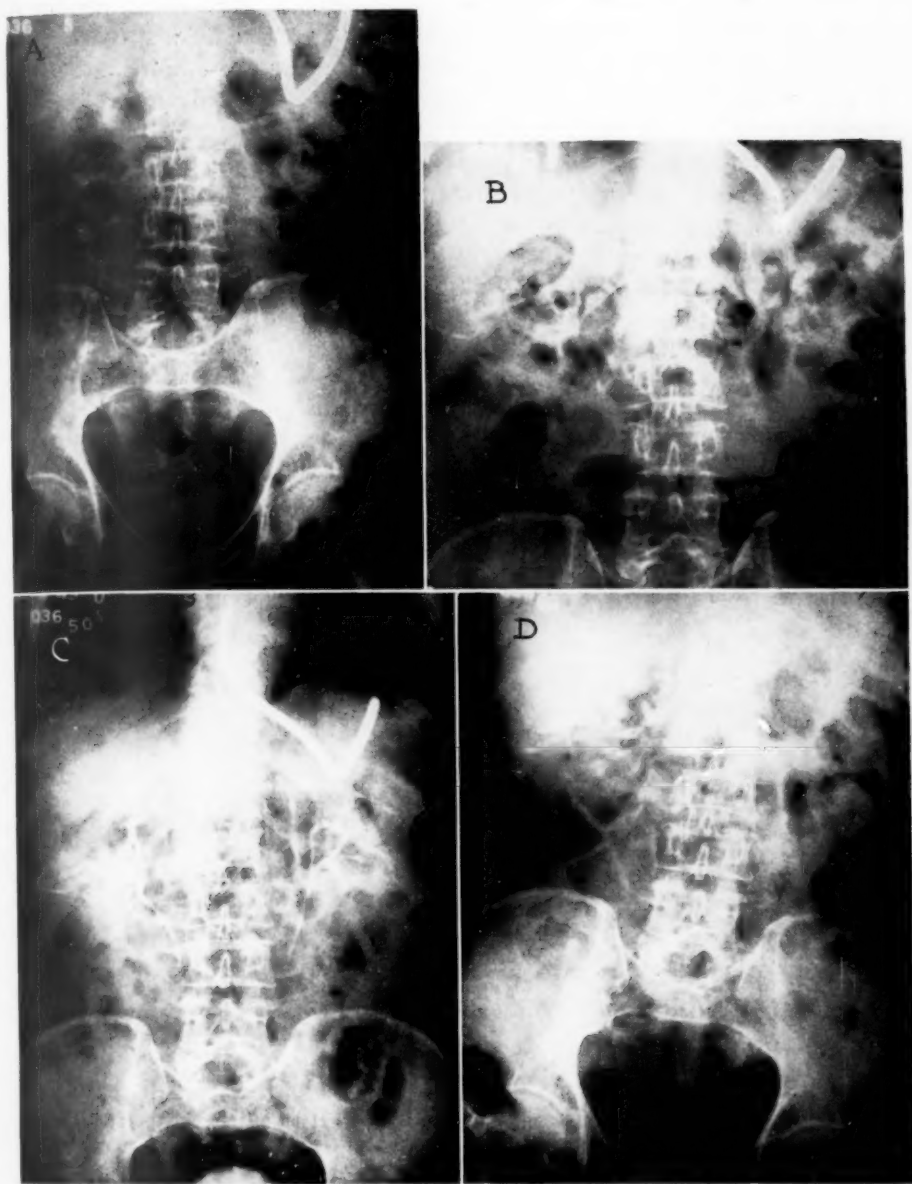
Roentgenograms of nervous patient, L. S., who had 1345 cc. of gastric gas aspirated during the 64 minutes of the intravenous pyelography. (A.) The initial film, just after the Levine tube had been inserted, shows a moderate amount of gas in the stomach and intestines. (B.) Twenty minutes after the intravenous dye injection, 460 cc. of gas aspirated. At least the stomach is empty. (C.) Fifty minutes after the dye injection, 1175 cc. of gas aspirated. Intestinal gas seems a little less than in A and B. (D.) Sixty minutes after the dye injection a total of 1345 cc. of gas had been aspirated. Six minutes before this film was taken the gastric tube was removed and gas is now seen in the stomach. The rapid ingestion of air is evident.
